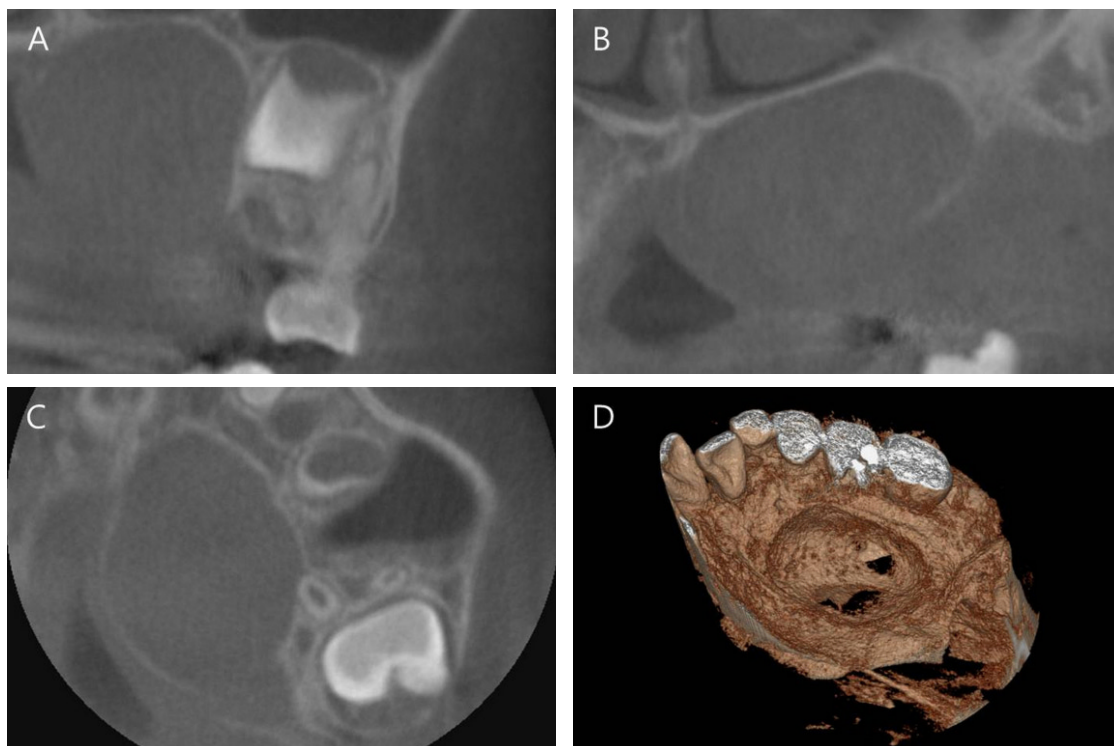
(A), (B) axial CT cuts. (C) coronal CT cut. (D) 3-dimensional CT cut. Computed tomography cuts showed well-circumscribed nodule on the hard palate which had no invasion to peripheral tissue.
